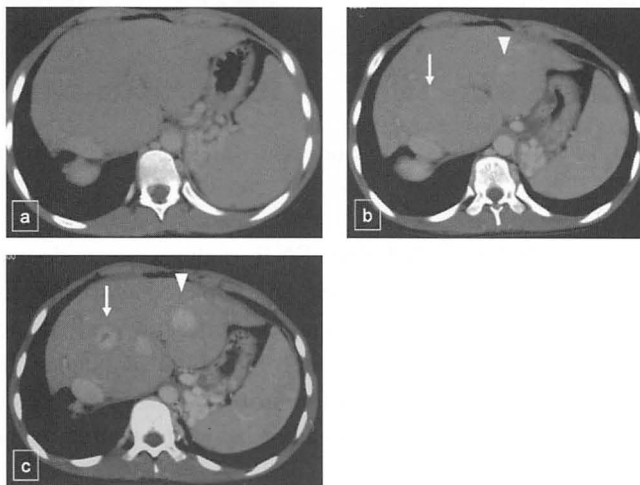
CT image (Delayed phase)
